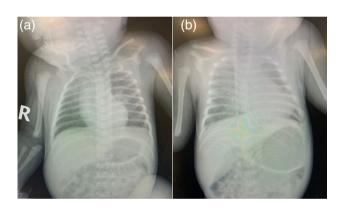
Chest X-ray of babies suffering from pneumonia. (a) Anterior– posterior view of chest X-ray of 1-day-old baby (case 10) shows bilateral diffuse pulmonary infiltrates and ground glass appearance with normal size heart shadow. (b) Anterior–posterior view of chest X-ray of 20-dayold baby (case 12) shows bilateral diffuse ground glass appearance with localised area on the right upper-lung lobe of dense infiltration with normal heart and bone shadow.
